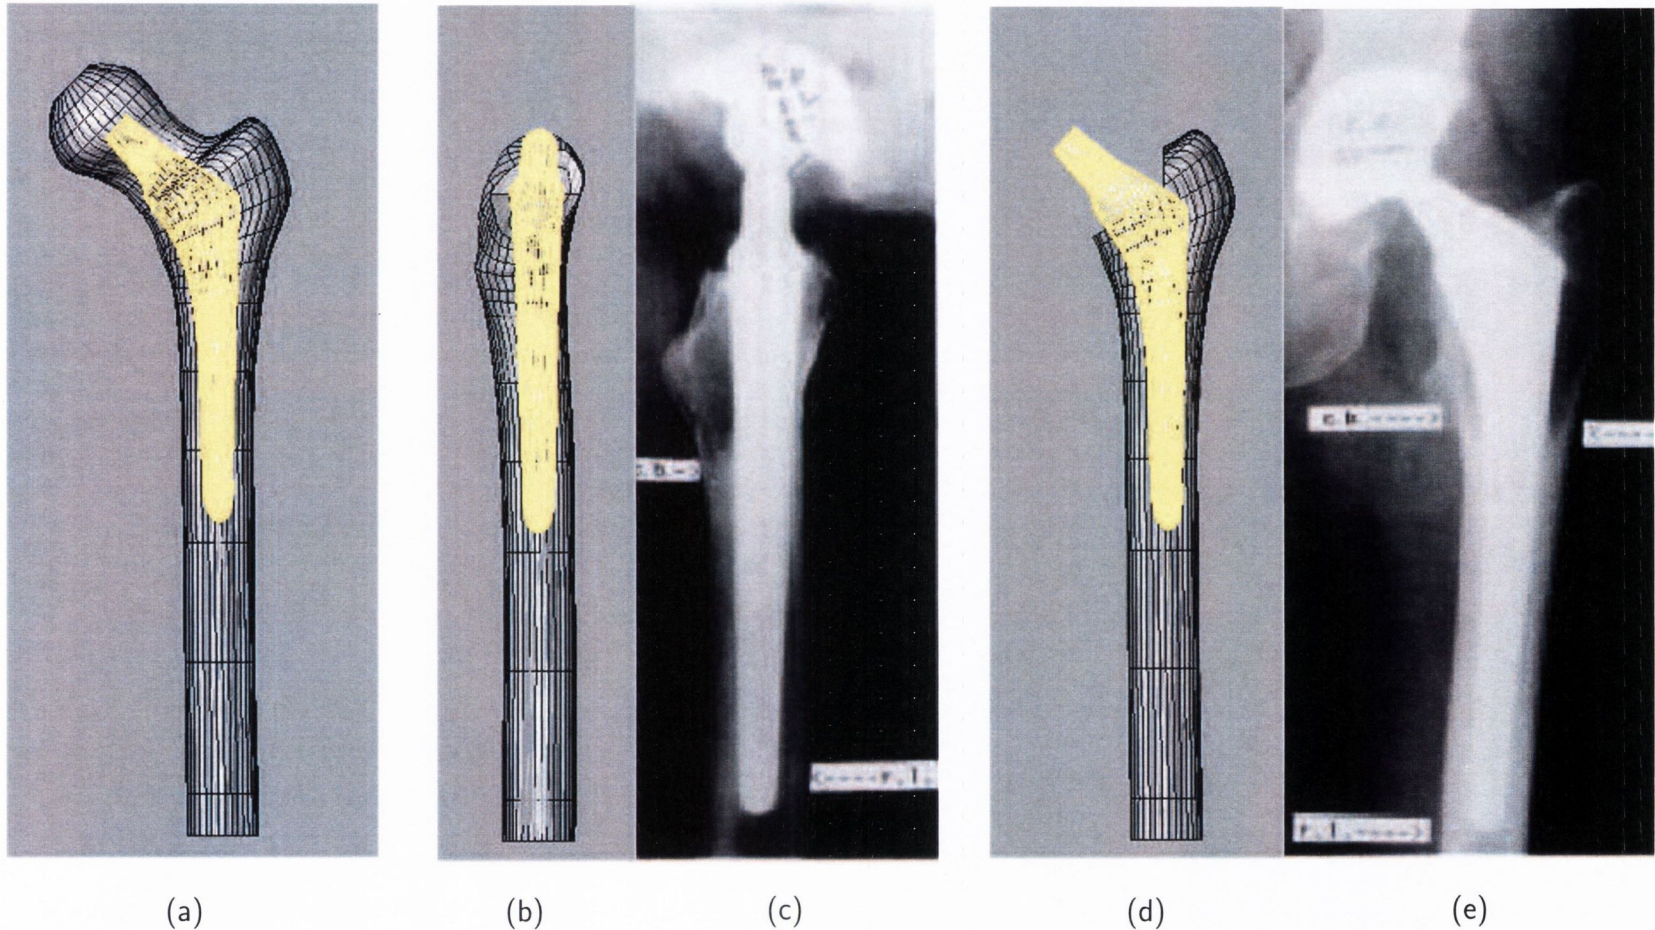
Stem resection and positioning (a) positioning of stem in the intact femur, (b) medial view of stem position with head resected, (c) medial radiograph (taken from D'Antonio et al. (1992)), (d) anterior view of stem position with head resected, and (e) anterior radiograph (taken from D'Antonio et al. (1992)).
